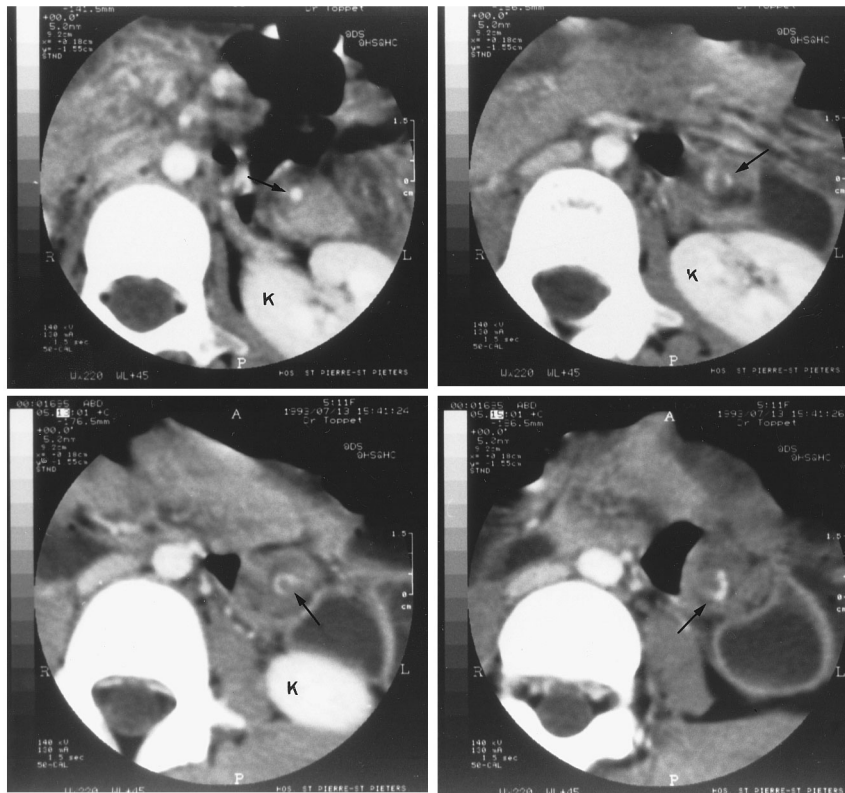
CT study. Serial cuts through the twisted vascular pedicle (arrow) of the spleen from kidney (K) down to the splenic hilum in the pelvis (total length of 4 cm): characteristic whorled appearance.
